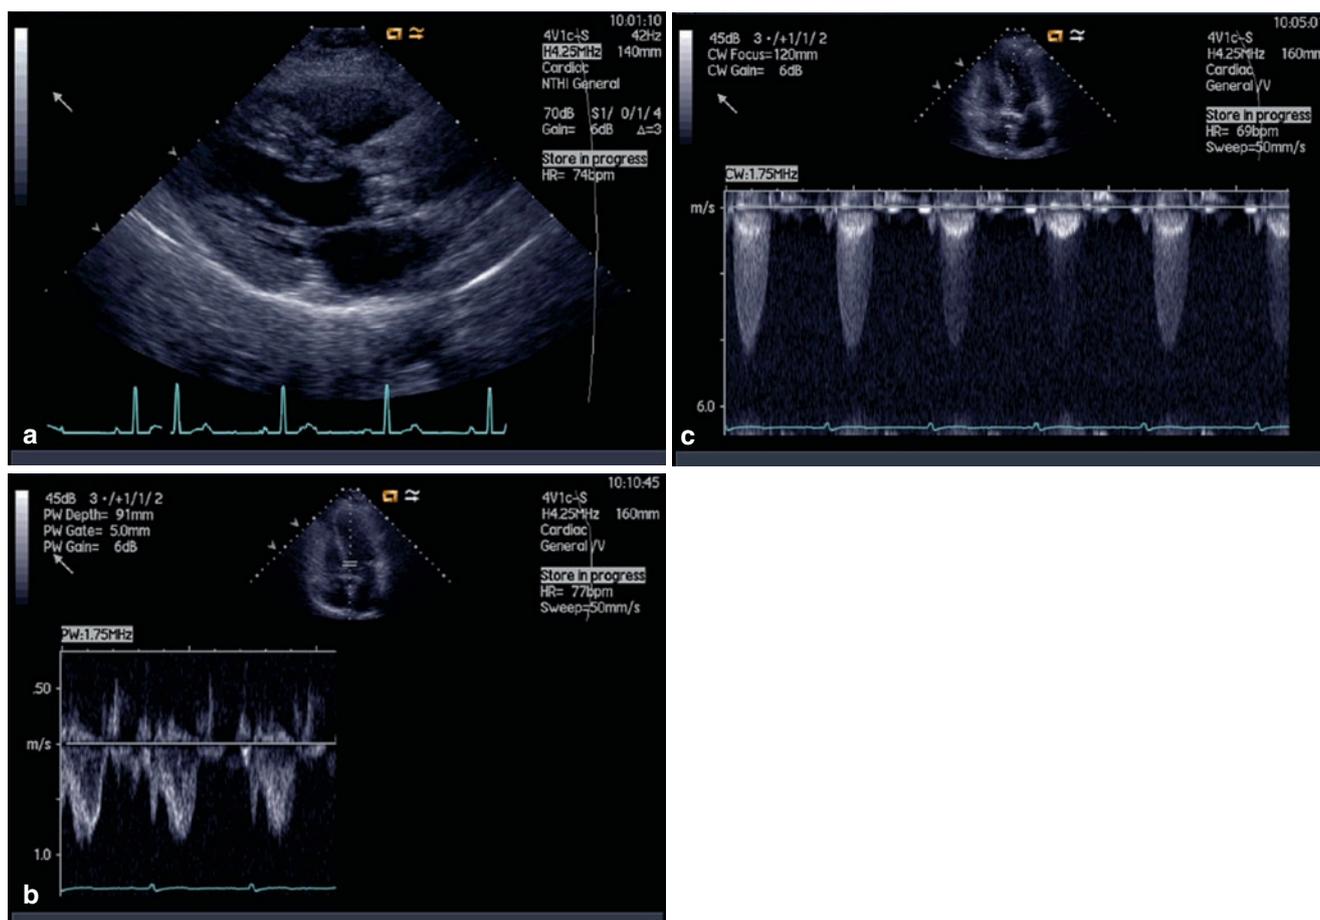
Continuity equation: Required recordings. (a) Parasternal long-axis view with the LV outflow tract diameter measurement. (b) Pulsed-wave Doppler recording of LVOT velocity obtained from an
